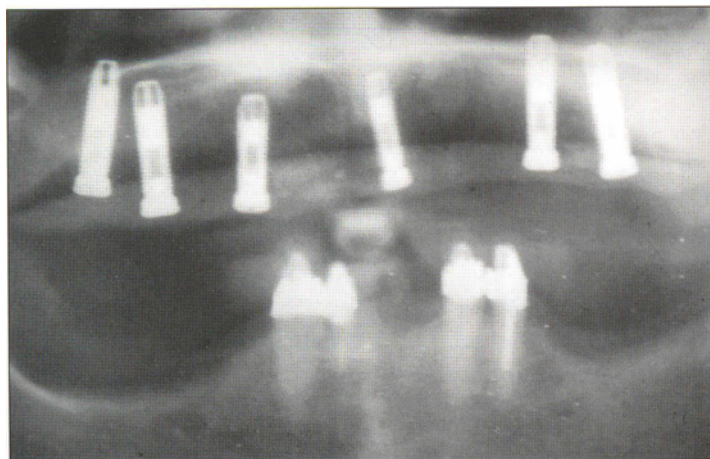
Postoperative panoramic radiograph of the patient in Fig 18-6a. Note the small amount of ridge height available for primary implant stabilization.
